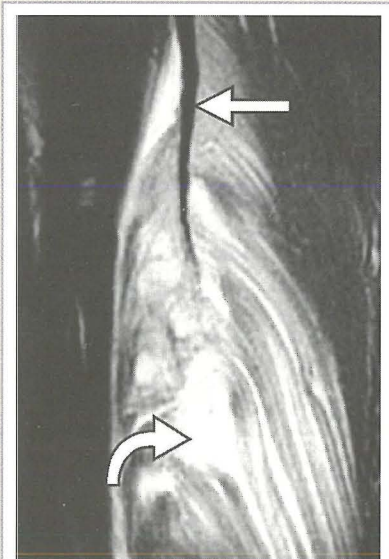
26-year-old professional football player who presented with recurring hamstring strains and prolonged rehabilitation periods. Coronal MR image shows hyperintensity (curved arrow) in the MTJ of the biceps femoris in keeping with myofibrillar disruption and retraction from the central tendon slip (straight arrow).
